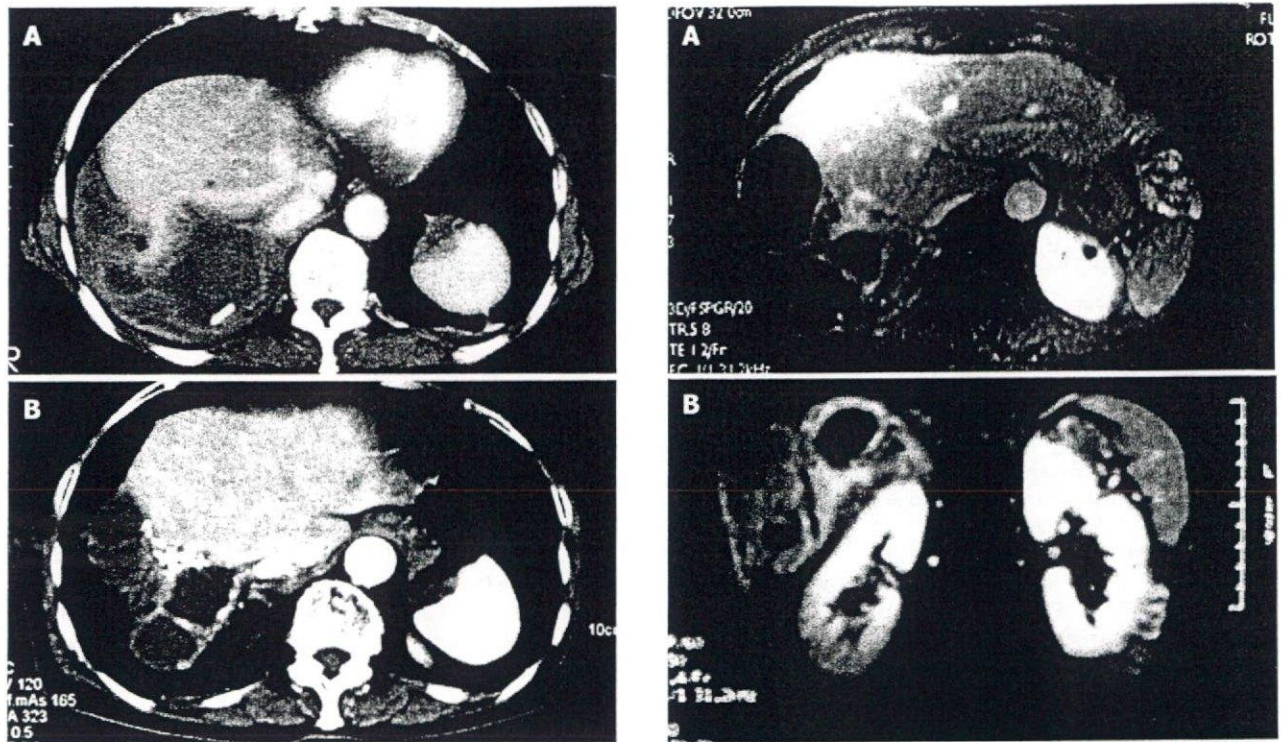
Computed tomography revealed a huge multilocular cyst measuring 10 cm in the right lobe of the liver on September 11th, 1997 (A). A similar cyst with a calcified lesion was found in the right lobe of the liver on May 15th, 2003 (B).
